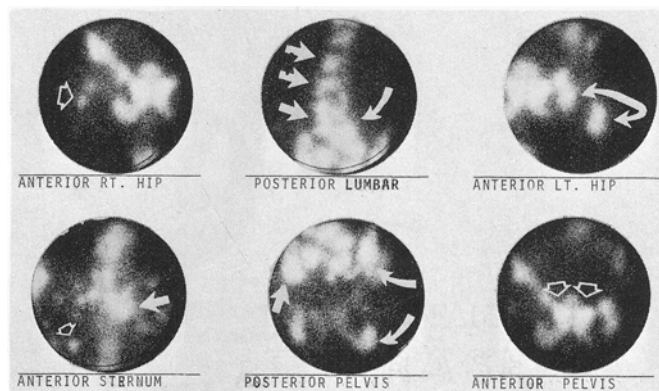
Man had history of prostatic carcinoma and was complaining of pain in right rib area. X-ray examination showed destructive process in right 4th rib anteriorly. Isotopic bone study shows increased activity in most of skeletal system. All of areas indicated are indicative of metastatic disease process.
